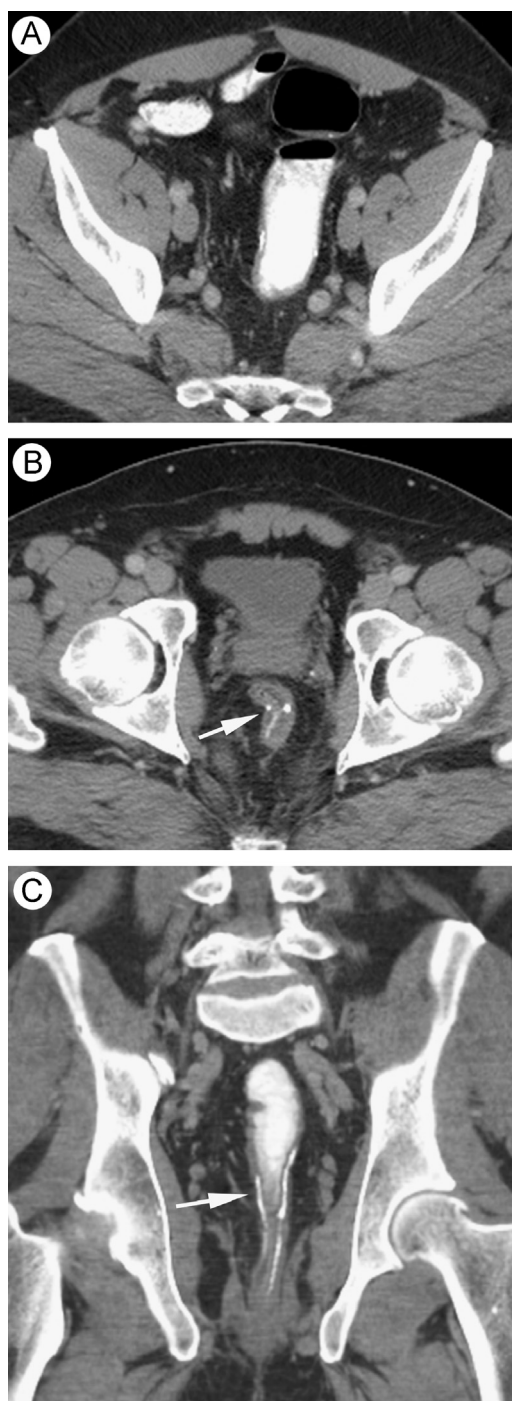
In this patient with ulcerative colitis, following IPAA, axial CT images proximal (A) and at the stricture (B, arrow) show a clear caliber change which is seen as a 4-cm narrowing in the distal ileal pouch just proximal to the anal anastomosis (arrow) on the coronal CT image (C).
